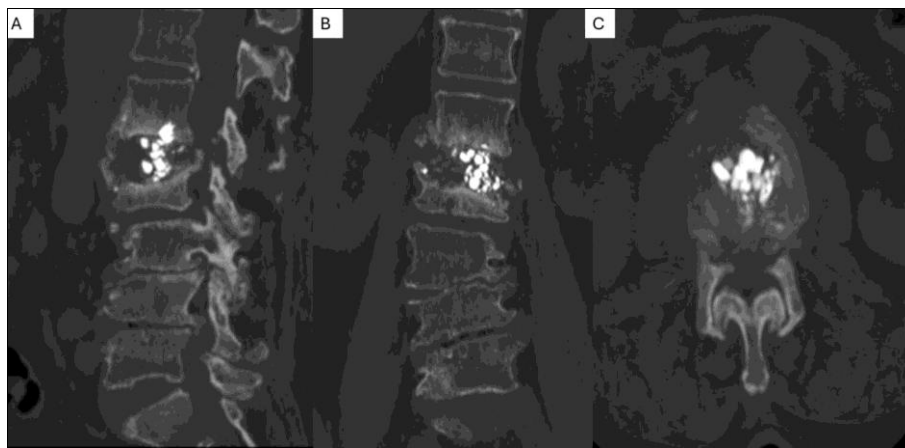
Eight-month post-L2 vertebroplasty follow-up Computed tomography scan – showing fragmented PMMA cement particles with destruction of the L2 vertebral body. A) Sagittal section B) Coronal section C) Axial section
